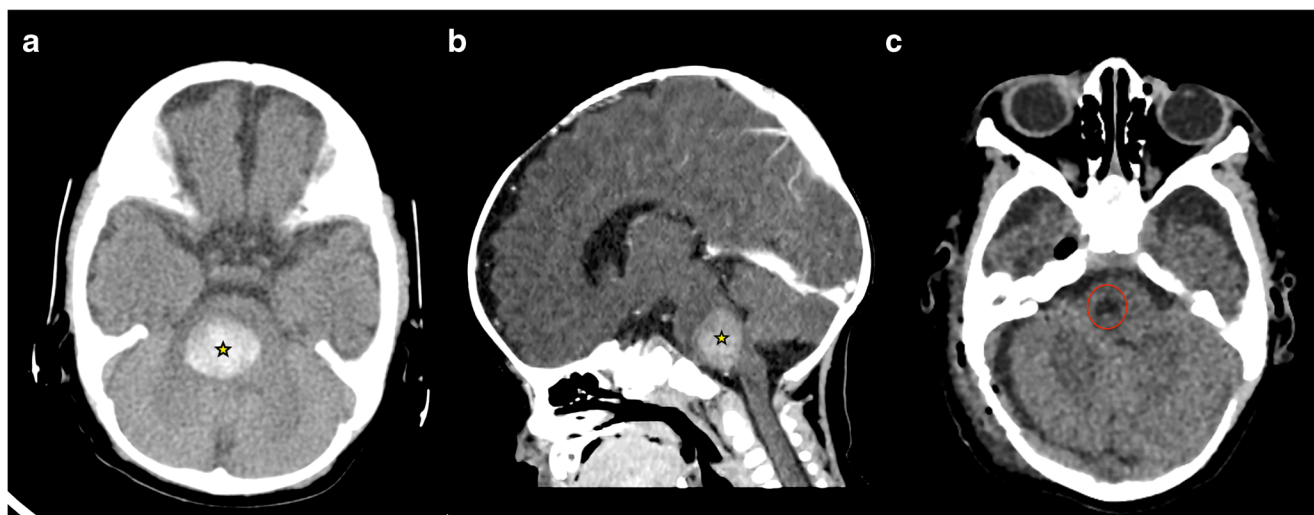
Non-contrasted preoperative CT scan (special pediatric low radiation protocol); (a) axial section; (b) sagittal reconstruction) of case 2, showing a spontaneously hyperdense mass within the pons (yellow star), signaling a significant acute hemorrhage and significant mass effect on the 4th ventricle. Non-contrasted postoperative CT scan (special
